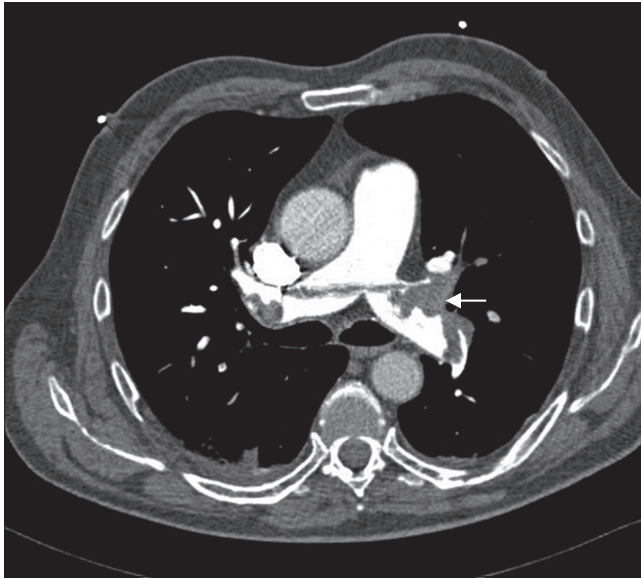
Cardiovascular computed tomography. Angiography of the pulmonary arteries. Massive pulmonary embolism (arrow)
